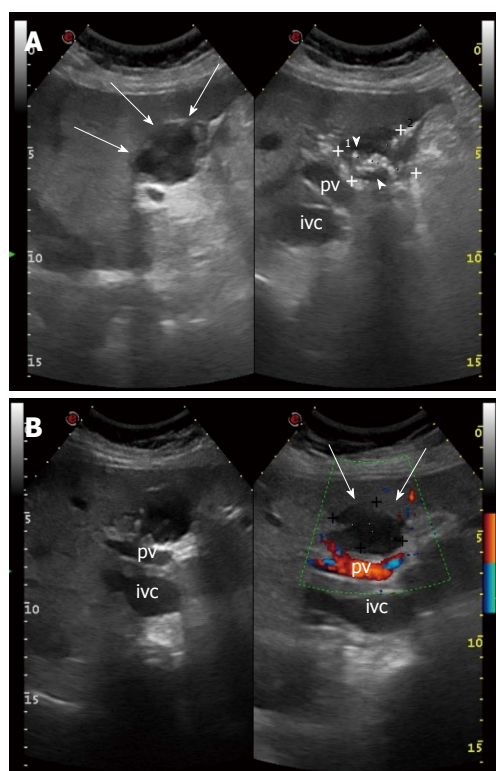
Chronic biloma in a 72-year-old woman: ultrasound findings. A: Oblique view shows a heterogeneous hypo-anechoic rounded lesion with hyper-echoic, calcified walls (arrows), numerous hyperechoic debris generating acoustic shadow (arrow heads) and maximum size of 3.89 cm (caliper 1) × 3.42 cm (caliper 2); B: Color Doppler sonogram shows absence of vascularity inside the lesion (arrows). pv: Portal vein; ivc: Inferior vena cava.
